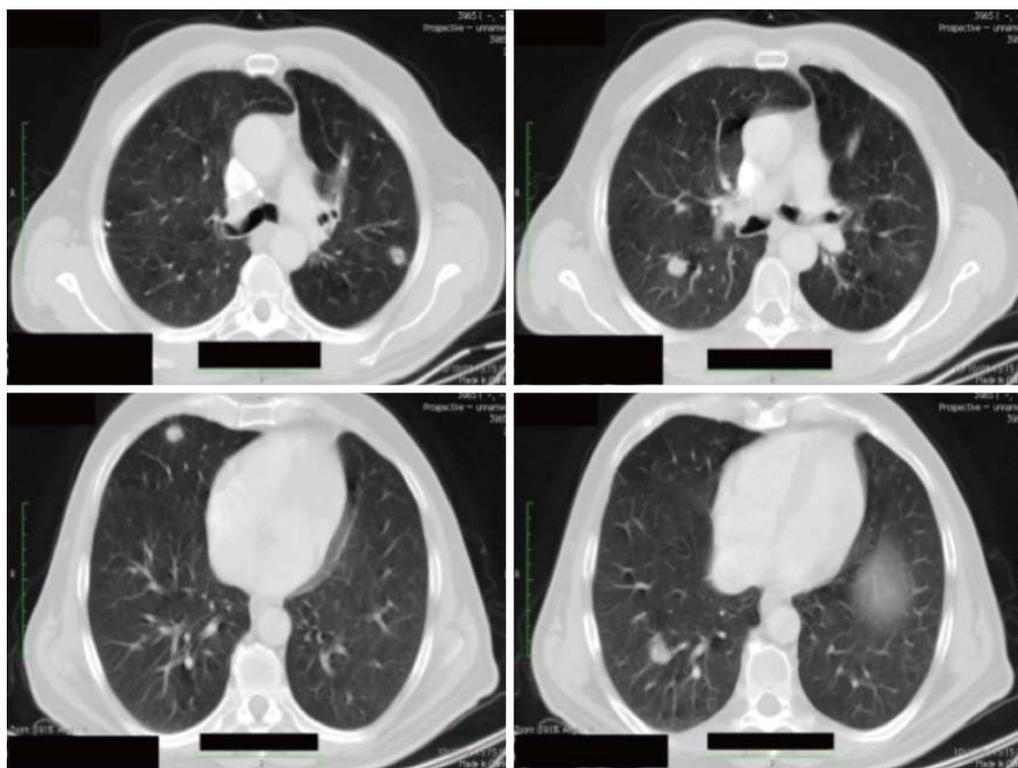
Thorax computed tomography-scan before starting chemotherapy (October 2008).
